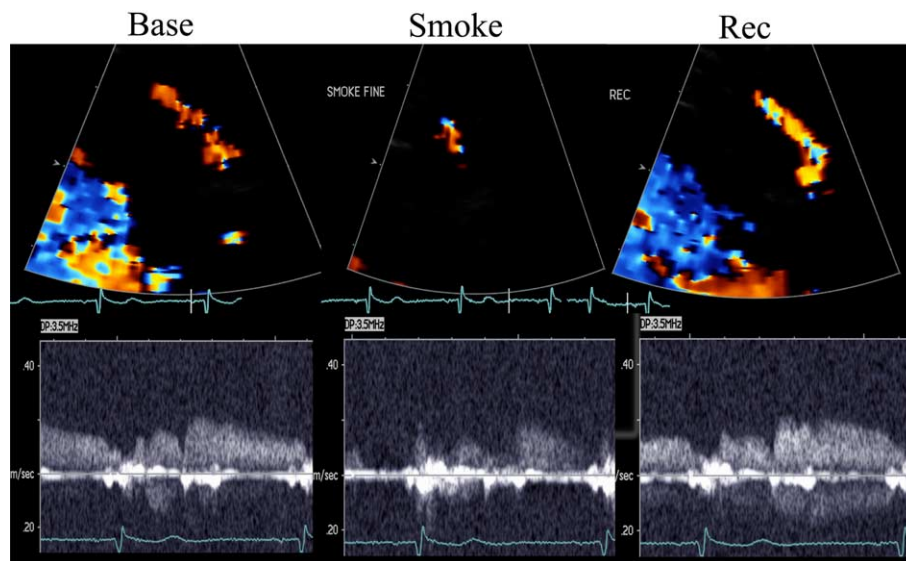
The effect of smoke on colour-Doppler ultrasound imaging and pulsed Doppler tracing. Coronary vasoconstriction caused by smoking is detected as a reduction in colour-Doppler flow signal, corresponding to a reduction in pulsed Doppler ultrasound intensity, which is followed by a recovery phase, characterized by some reactive hyperaemia.
